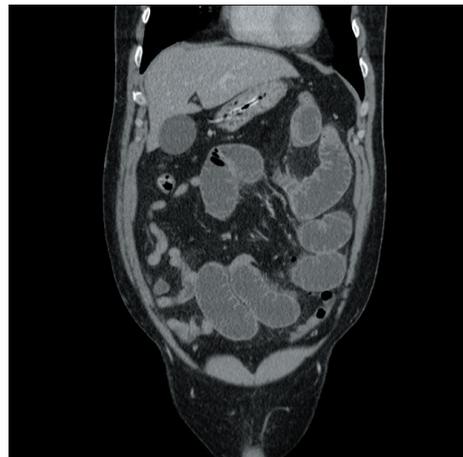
Coronal reconstruction of CT showing dilated proximal small bowel loops.
